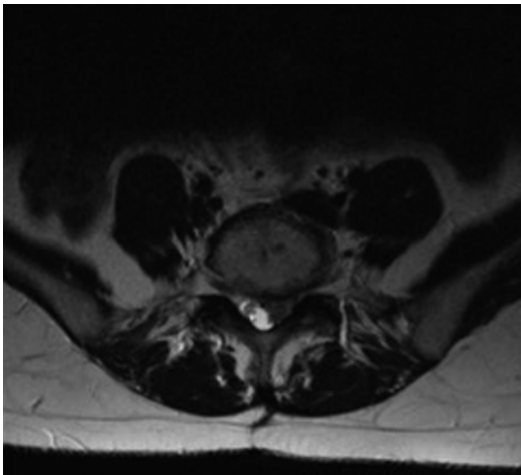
The axial MR T2-weighted image clearly demonstrates nerve root compression of S1 on the left side due to herniated disk material
